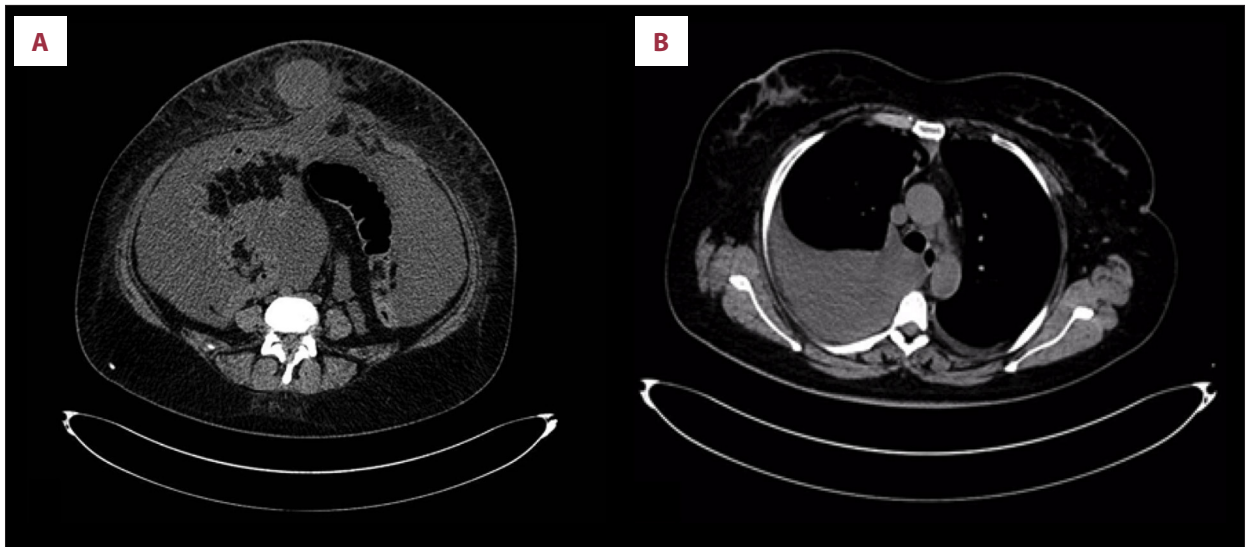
Computed tomography (CT) scans at the start of treatment. (A) Abdominal CT scan showing carcinomatosis. (B) Thoracic CT scan showing pleural effusion.
